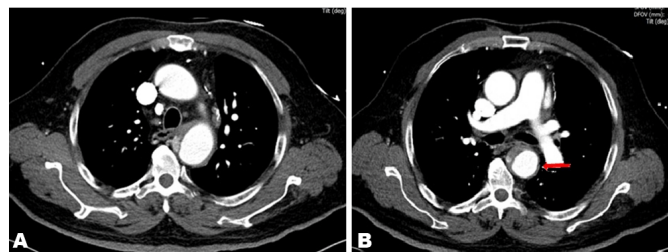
(A, B): Computed tomography scan revealing crescentic high attenuation at the descending aortic arch which extends to the aortic hiatus.
